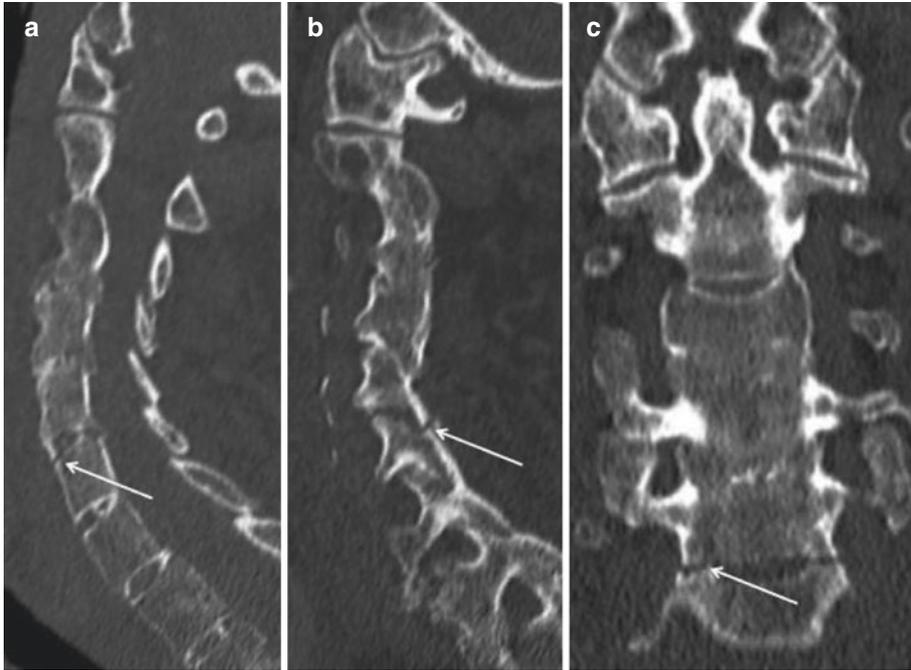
Midline (a) and para-central (b) sagittal, as well as a coronal (c) CT scan. The arrows point to the 3-column chalk-stick fracture
